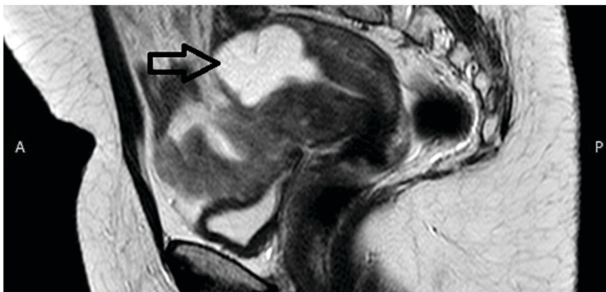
Magnetic resonance image, which confirmed the diagnosis of cystic adenomyosis (marked with an arrow).
